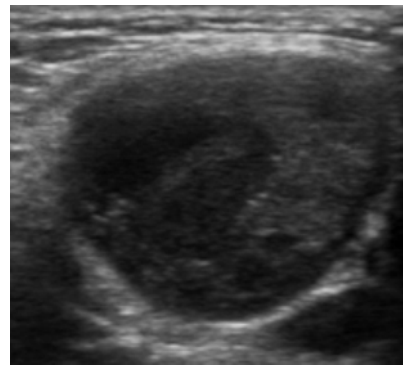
Ultrasound image shows a well-defined, mixed density, predominantly hypoechoic mass lesion involving the left parotid gland with internal cystic areas. No evidence of any calcification noted.
